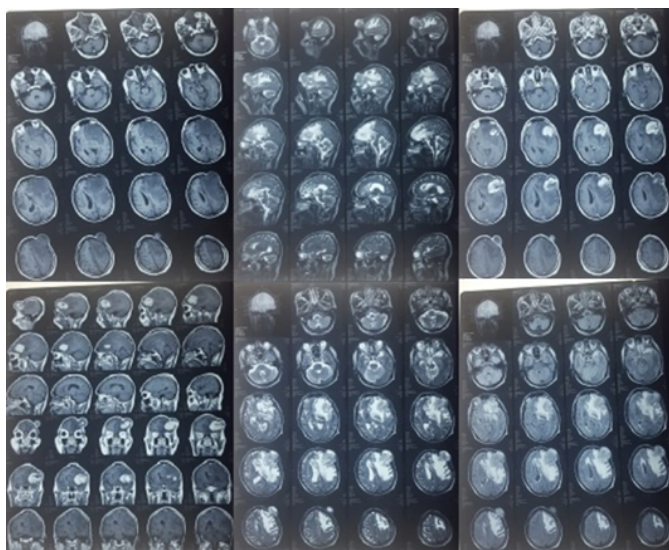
Post-surgical head MRI with contrast.
